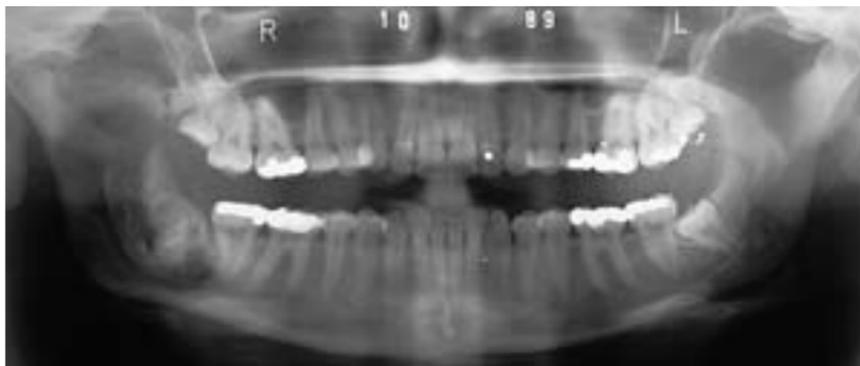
Ameloblastic fibro-odontoma. The panoramic radiograph of a 20-year-old female reveals a dysplastic tooth 48 with irregular calcifications. Radiographic signs of the slow, nonaggressive expansion of the lesion include impingement of the mandibular canal and tooth 47. In contrast to the various shapes and forms of a complex odontoma, the demarcation in this case is not clearly defined around the lesion.
